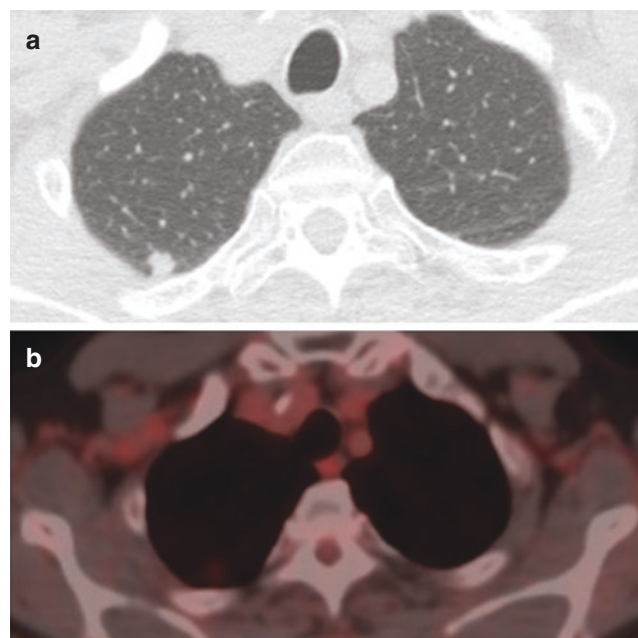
Chest CT showing a subpleural spiculated nodule (a) with hypermetabolism on PET (b) in the right upper lobe
